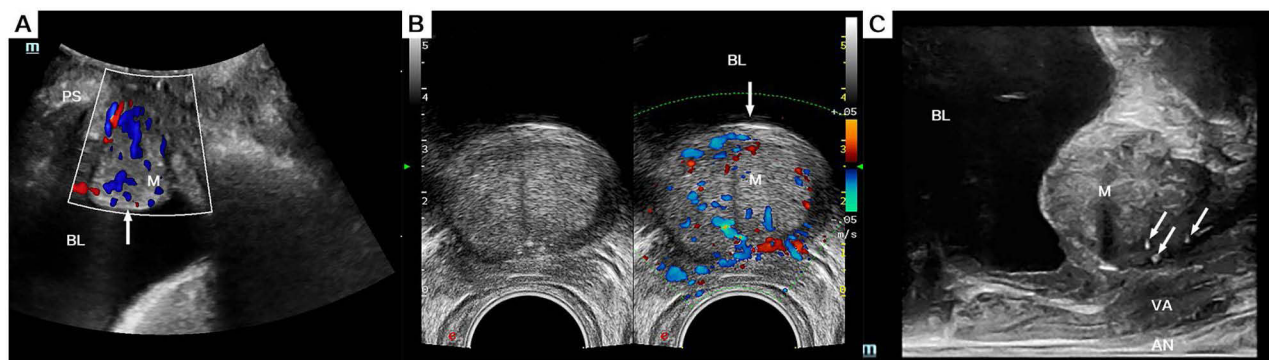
Transperineal (convex probe) ultrasound (A) a moderately echogenic solid mass is seen in the proximal urethra, with clear borders, convexity to the bladder, and abundant blood flow signal. Transrectal (convex array probe) ultrasound (B) the shape of the mass is like a chestnut, similar to the male “prostate”, with disturbed vascularization. Transrectal (linear probe) ultrasound (C) the mass is slightly lobulated, which can clearly show multiple punctate echoes (white arrows) within the mass and distinguish the mass from the urethra and vagina.
